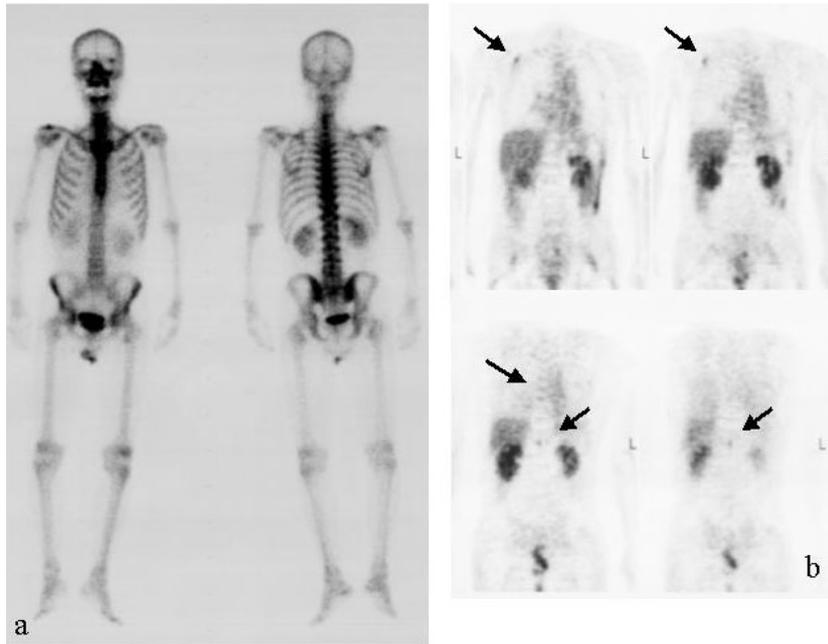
A false positive case of FDG-PET. Sixty-one-year-old male patient with hepatocellular carcinoma, post-treatment. In the follow-up period after transarterial-embolization (TAE) of the primary lesion, he received BS and FDG-PET without any evident sign of recurrence (a, b). BS showed a normal uptake pattern of ^{99m}Tc -HMDP, but whole-body PET scan showed increased uptake of FDG in right chest wall and vertebrae (b). Multiple bone metastases were diagnosed by PET without clinical information, whereas PET diagnosis with clinical information did not suspect these lesions as bone metastases because of low tumor marker value. Follow-up clinical information confirmed that these were not metastatic lesions.
